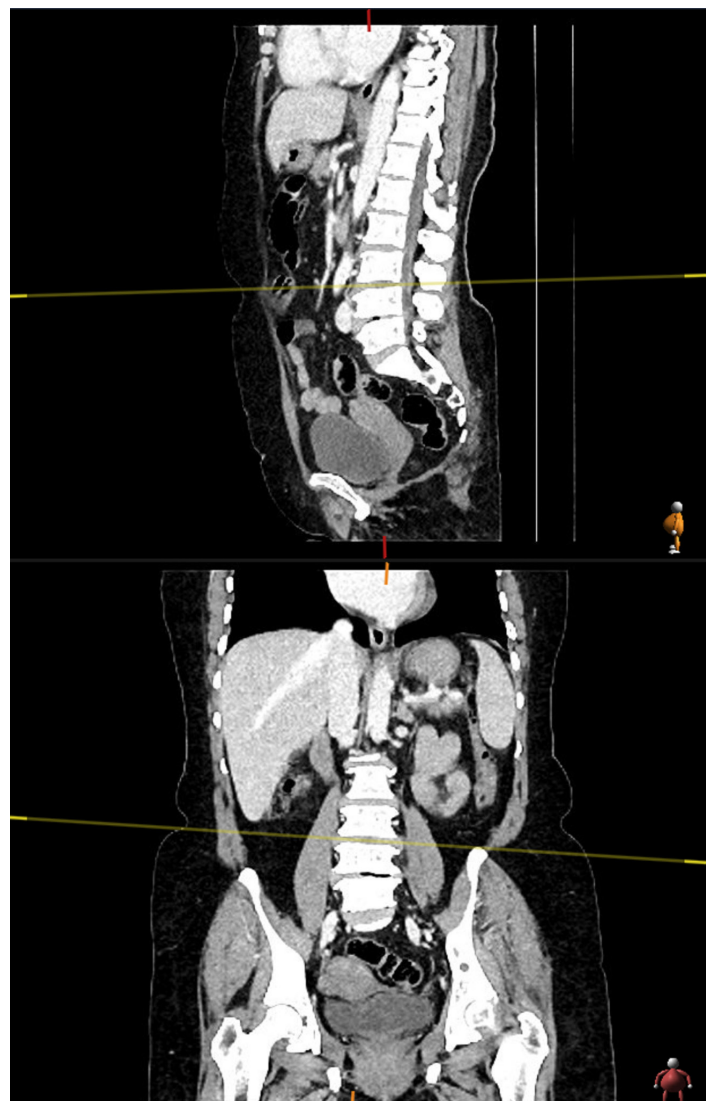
An example of level determination for PSMAI measurement in sagittal and coronal sections
